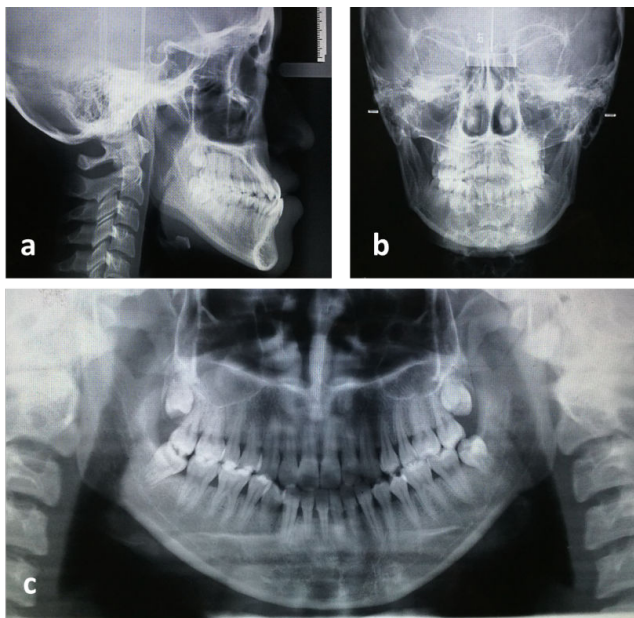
Pretreatment radiographs. a: pretreatment lateral cephalogram; b: pretreatment frontal cephalogram; c: panoramic radiograph.
